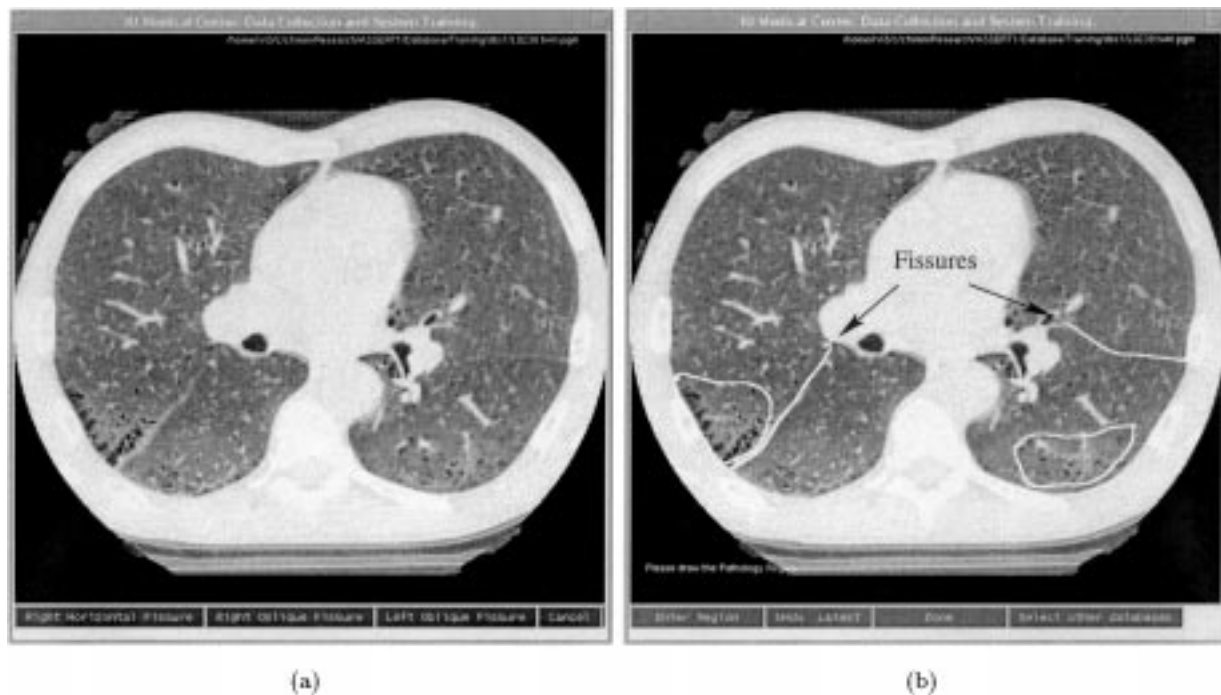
Shown here are (a) an HRCT lung image, (b) the same image after a physician has delineated the PBRs and the fissures by dragging the screen pointer. Each PBR is delineated by an enclosing contour. Black arrows point to the fissures highlighted by the physician.
